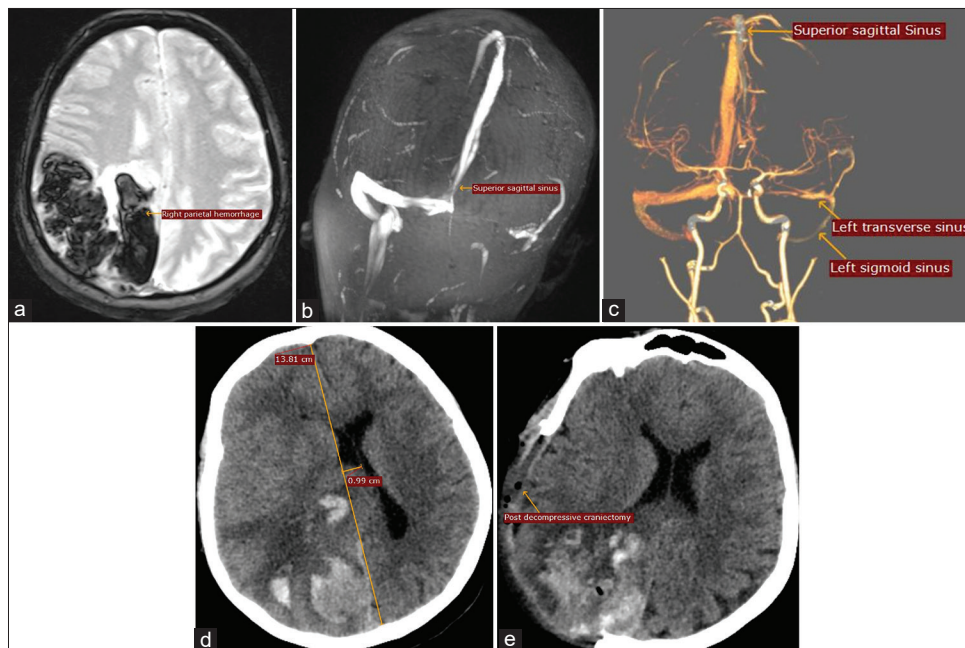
(a) MRI brain T2-weighted-GRE axial view showing right parietal hemorrhage. (b) MR venogram 2D TOF MIP coronal view showing complete thrombosis of the left transverse and sigmoid sinuses and partial thrombosis of superior sagittal sinus. (c) CT venogram 3D volume rendering technique showing complete thrombosis of the left transverse and sigmoid sinuses and partial thrombosis of superior sagittal sinus. (d) CT brain axial view showing increase in midline shift. (e) CT axial view after right parietal decompression craniectomy.
